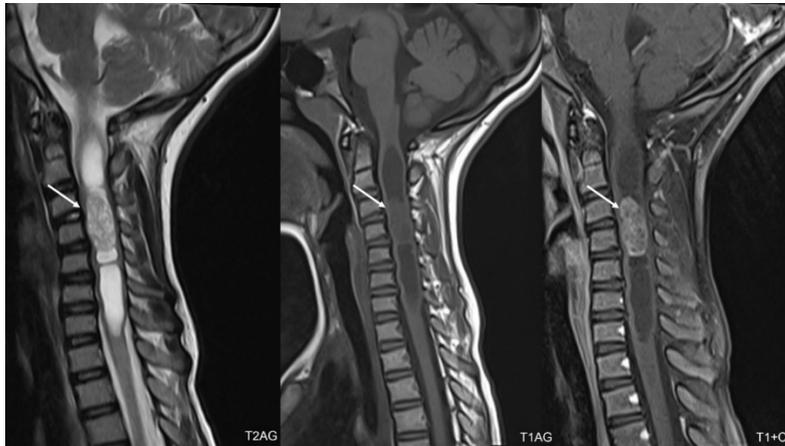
Cervical ependymoma; contrast-enhanced cervical MRI demonstrates an enhancing solid lesion and peritumoral cystic components at the cervical spinal cord (arrows).
